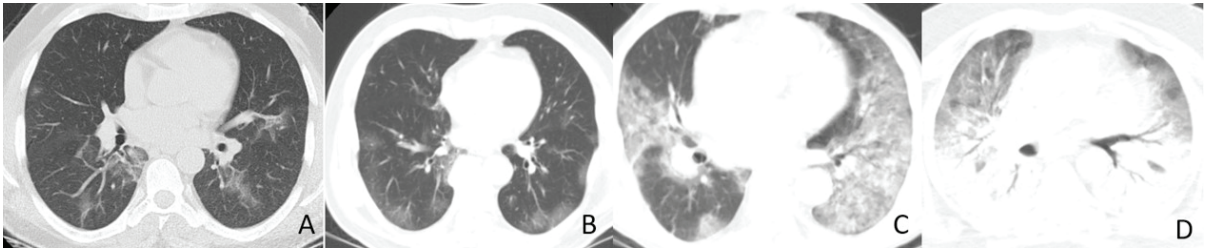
Representative computed tomography (CT) images of COVID-19 pneumonia. The CT images show multifocal bilateral ground-glass opacities (A, B, C) and ground-glass opacities with consolidations(D). Total CT score was A:3, B:6, C:15 and D:20
